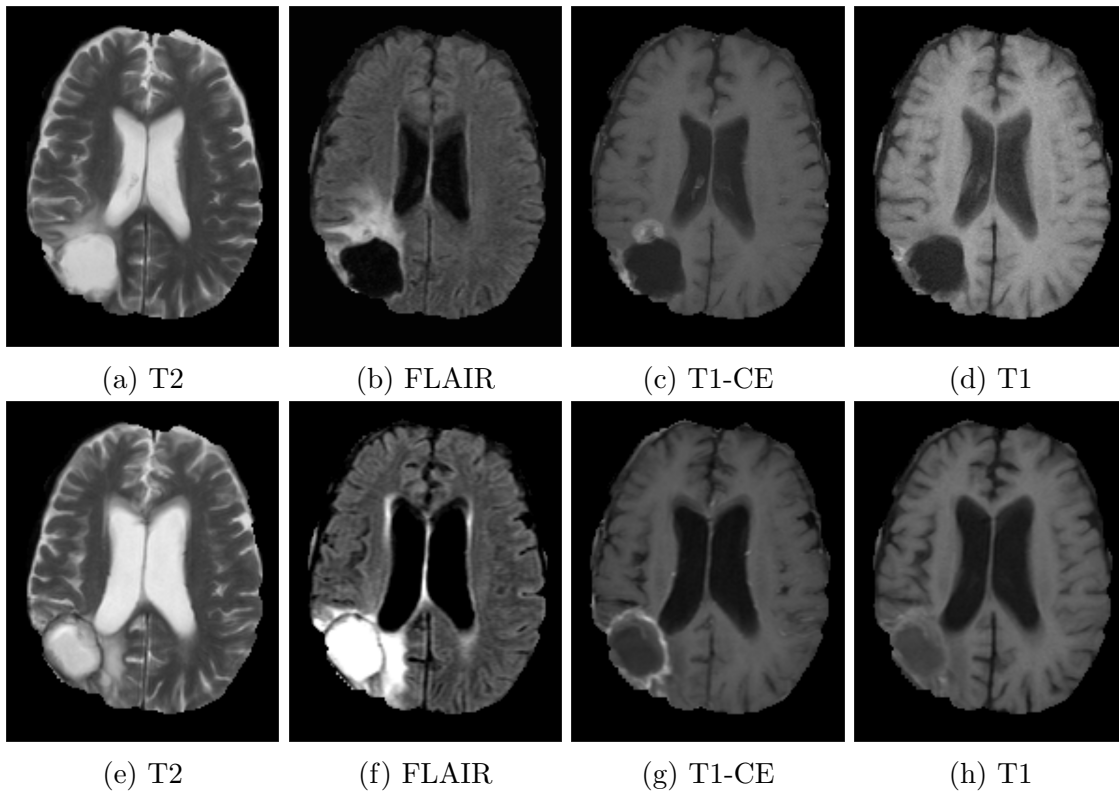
Resection cavity changes in two subsequent MRI acquisitions of the same patient. The first row contains four images, each showing different MRI sequences (T2 weighted, FLAIR, T1 weighted, and T1 contrast-enhanced) acquired during the same session. The second row shows the same sequences acquired in a subsequent session.
